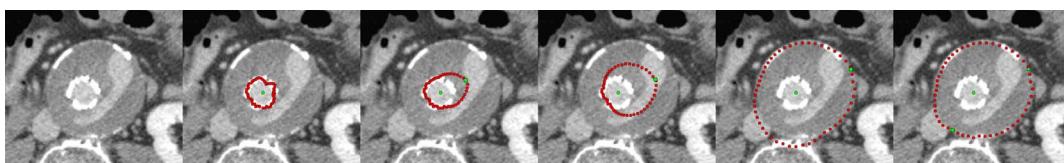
presents the interactive segmentation of a stented lumen and the thrombus from a postoperative computed tomography angiography (CTA) scan from a patient with an abdominal aortic aneurysm (AAA)<sup>23,24</sup>. The leftmost image shows the original scan and the second image from the left presents the segmentation of the stented lumen (red) with the initial user-defined seed point (green) placed inside the lumen (note: for the interactive segmentation a circle was used as template to construct the graph). The following three images show how the user places a second seed point and interactively drags it to the contour of the thrombus. However, the graph is still constructed from the initial seed point that has been placed at first inside the lumen. The second seed point forces the algorithm to perform the min-cut at its position and therefore also influences the positions of the min-cut in the neighboring rays. During the interactive dragging of the second seed inside the thrombus (images three and four from the left), the algorithm tries to adapt to other structures appearing in the thrombus. In this example, contrast enhanced blood from an endoleak<sup>25</sup> is visible (elongated bright area inside the thrombus), and the resulting contour partly fits to this endoleak in the third and the fourth image in the lower right area: once to the left contour of the endoleak (third image) and once to the right contour of the endoleak (fourth image). In the rightmost image, the segmentation outcome has furthermore been refined by an additional seed point placed by the user on the contour of the thrombus in the lower left.
